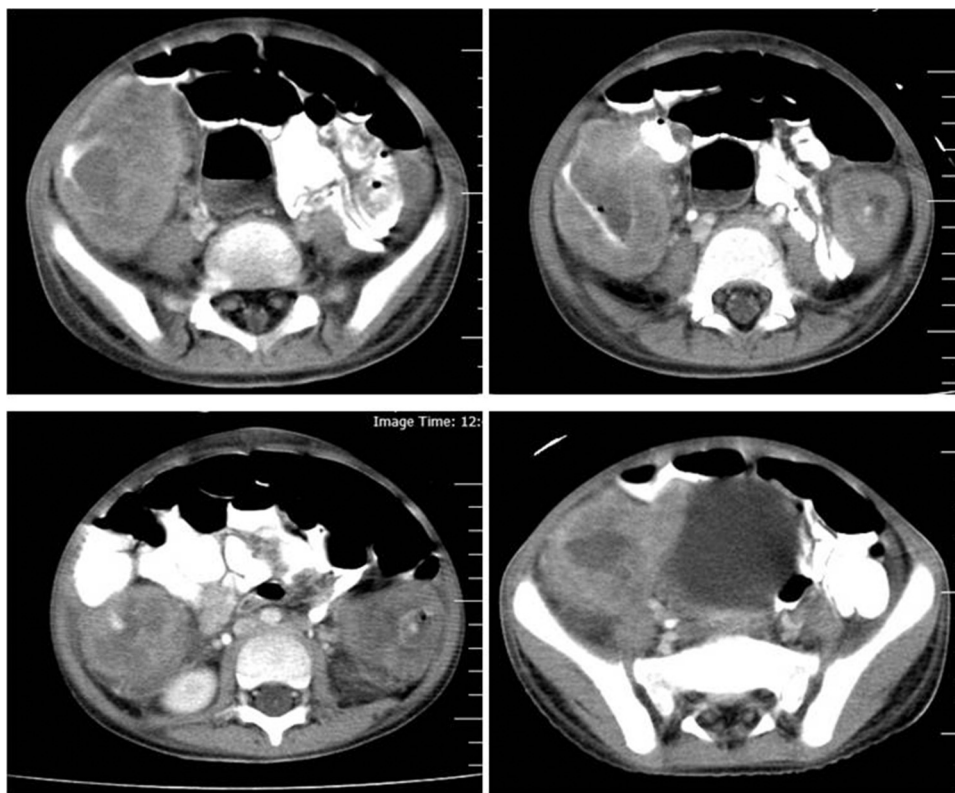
Abdominopelvic contrast-enhanced CT scan of our patient. Two extensive heterogeneous masses in the terminal ileum, which were extended to the cecum.
